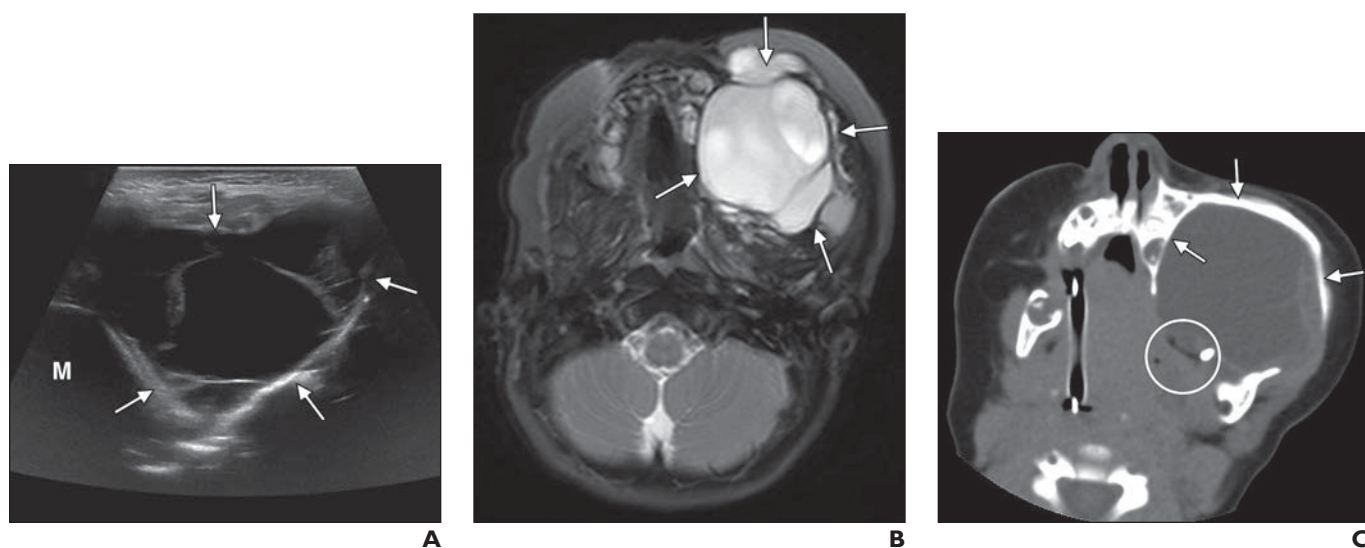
1-year-old girl with diagnosis of teratoma presenting with progressive painless facial swelling since birth. A, Ultrasound image of face shows large multiseptate cystic mass (arrows) in left cheek. M = malar bone. B, Axial T2-weighted MR image with fat saturation of face shows septate hyperintense left cheek mass (arrows) suggesting cystic nature. C, Axial CT image without contrast agent shows left cheek mass as hypodense due to cystic component. Peripheral nodule containing fat and coarse calcification (circle) is readily visible and highly suggestive of teratoma. Note bone remodeling involving left maxilla and zygomatic arch (arrows).
